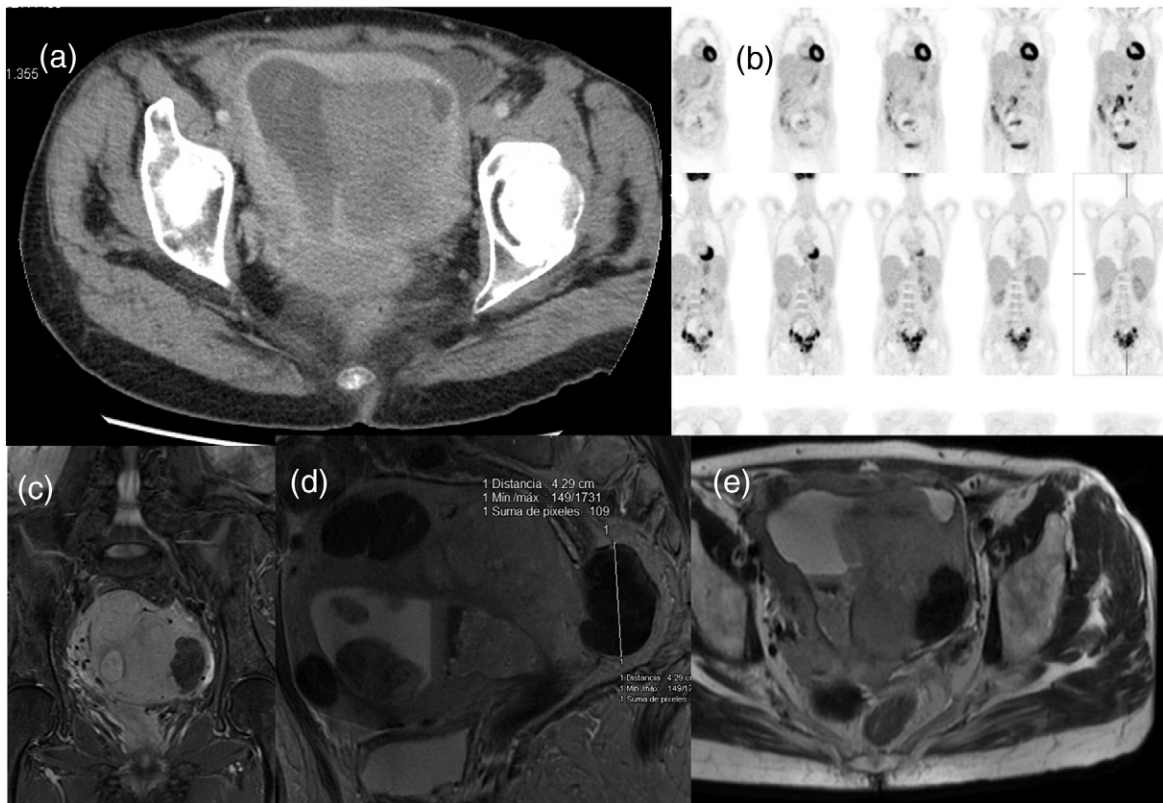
CT (a) and MRI scan (c, d, e) revealed an enlarged uterus with a contiguous mass in the uterine fundus (a). The PET scan showed an hypermetabolic image in the pelvic region with poorly defined morphology occupying the cervical stump and Pouch of Douglas, hypermetabolism deposits in the mesentery and peritoneum compatible with mesenteric implants, and an image in the left pubis that, in this context, could be a metastasis (b).
